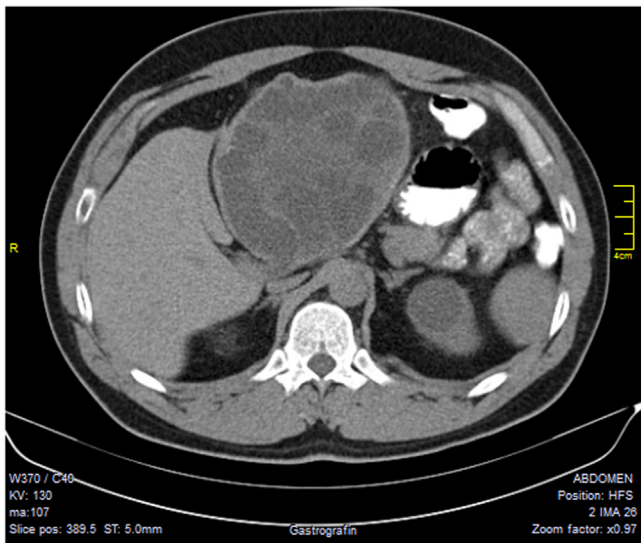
CT showing the huge cyst (25 cm) with the characteristic daughter cysts and clearly delineated reactive layer (pericystic wall) in the first case.
